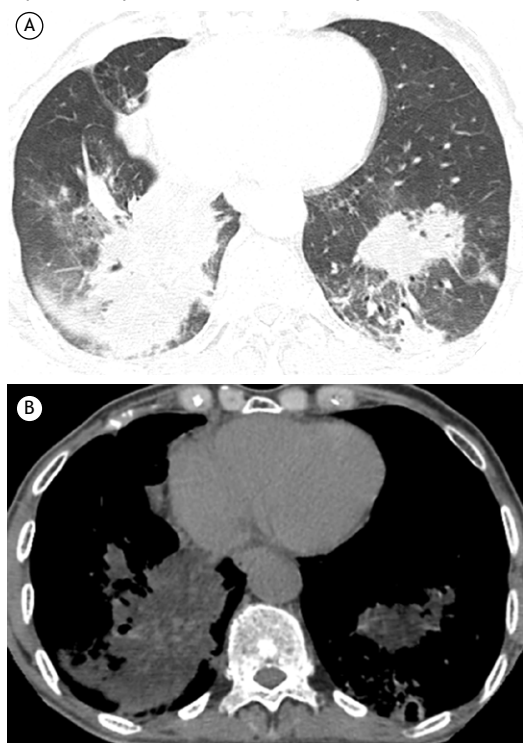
Axial CT scans at the level of the lower lobes, with lung and mediastinal window settings (A and B, respectively), showing bilateral areas of consolidation. Note that the density of the consolidation is lower than the density of the heart, with negative values ranging from -13 to -86 Hounsfield units.
